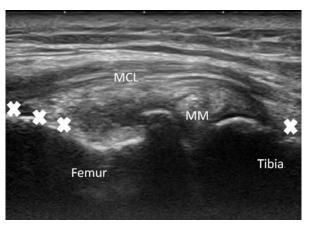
Musculoskeletal ultrasound, left medial knee: Protrusion of the meniscus and osteophytes. (MCL: Medial collateral ligament, MM: Medial meniscus, X: the injection sites)
